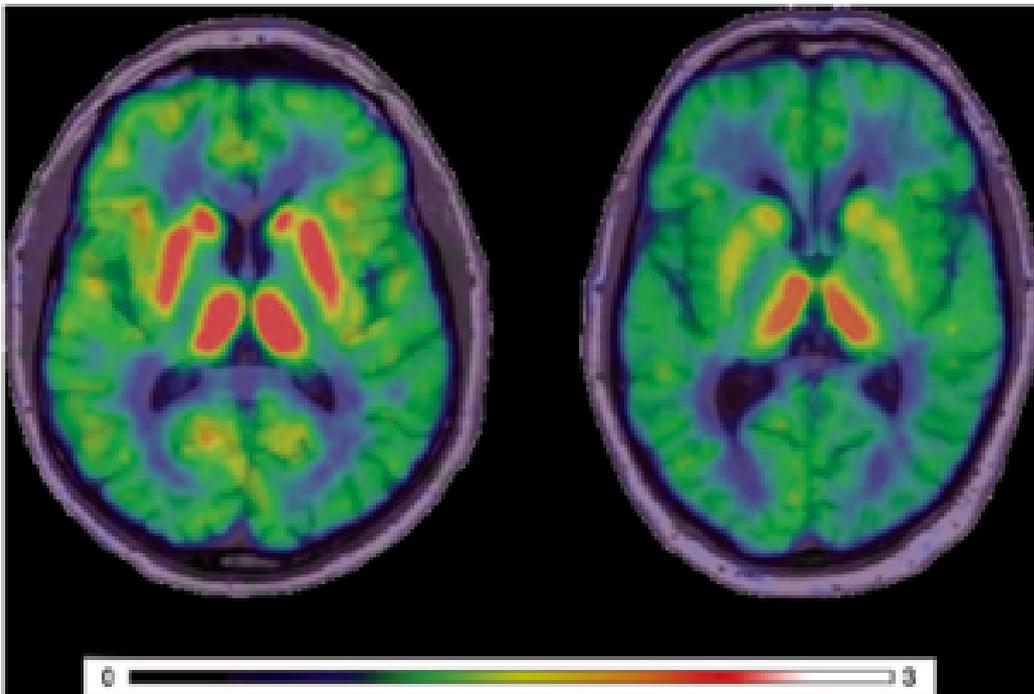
Reduced serotonergic innervation in Parkinson’s disease. Signals from 11C-DASB PET imaging co-registered with 1.5T MRI images show normal serotonergic innervation in the basal ganglia in a healthy subject (left) but markedly reduced in a PD patient at 16 years post-diagnosis (right). Reprint from [Politis et al. \(2015\)](#).
